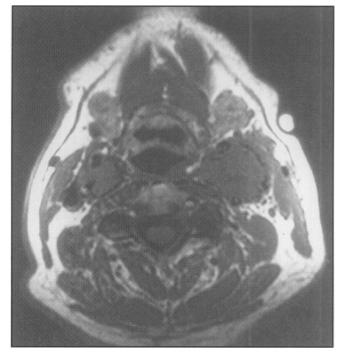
Axial T1-weighted (TR600/TE11) image through the neck (at the level of the carotid bifurcation).
